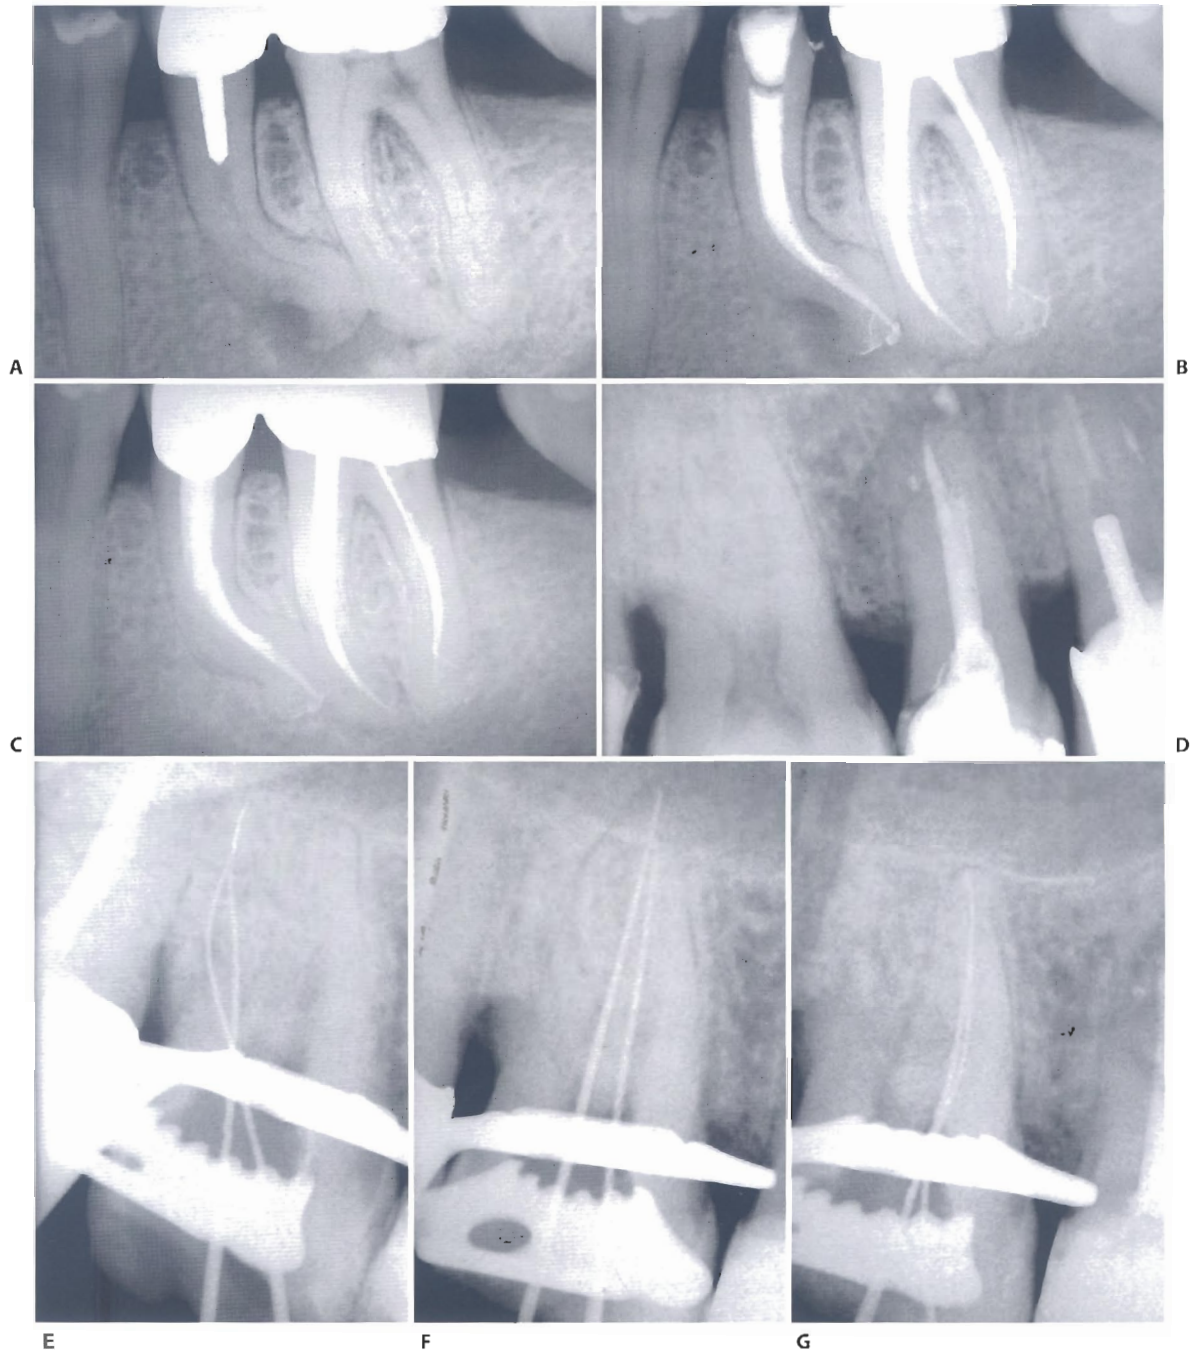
Clinical cases of teeth with canals having a complex original anatomy. In these cases manual preflaring will be more important in order to reduce stresses in the successive NiTi rotary instruments. A. Preoperative radiograph of a lower left second premolar. B. Postoperative radiograph. C. Follow up radiograph after one year (E. Berutti). D. Preoperative radiograph of the upper right first molar. E. Radiograph to check the working length of the distal canals. F. Radiograph to check the working length of the palatal canals. G. Radiograph to check working length of mesial canals (continued).
